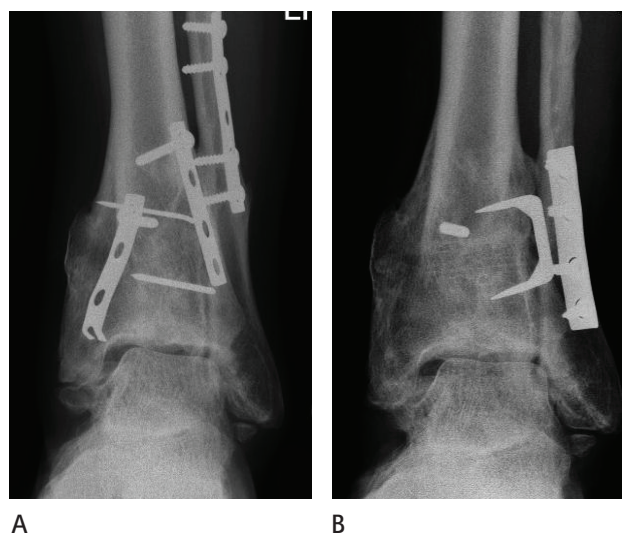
AP views of weight bearing x-rays of the left ankle of a 51 year old man before (A) and one year after (B) supramalleolar lateral closing wedge osteotomy and deltoid ligament release for early stage post traumatic varus ankle osteoarthritis based on extra articular deformity.
